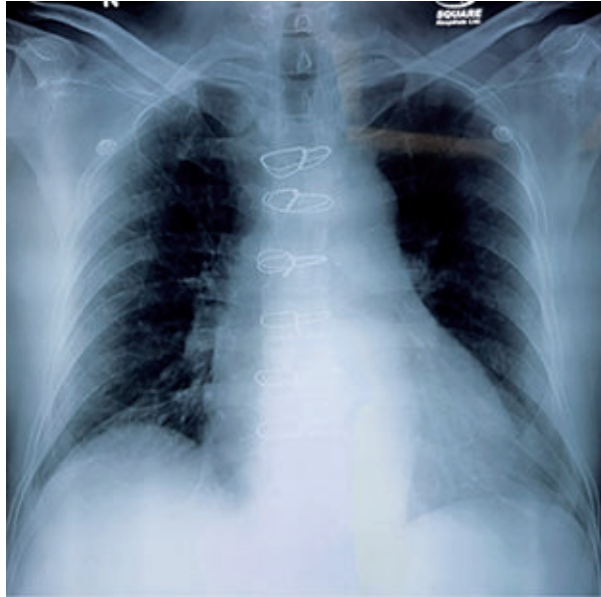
Pre-operative chest X-ray showing cardiomegaly and suture from previous surgery
